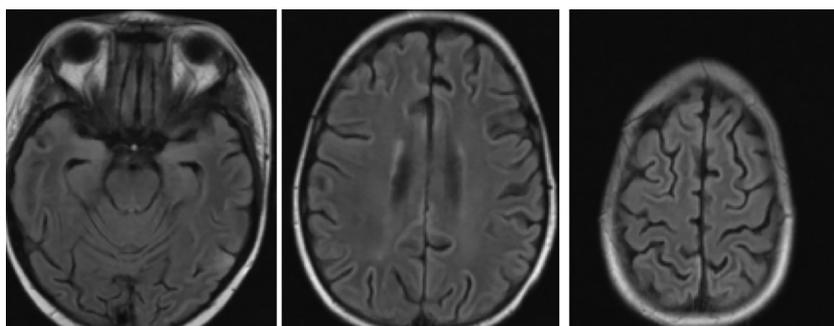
Brain MRI at D22 showing almost complete disappearance of abnormalities.
